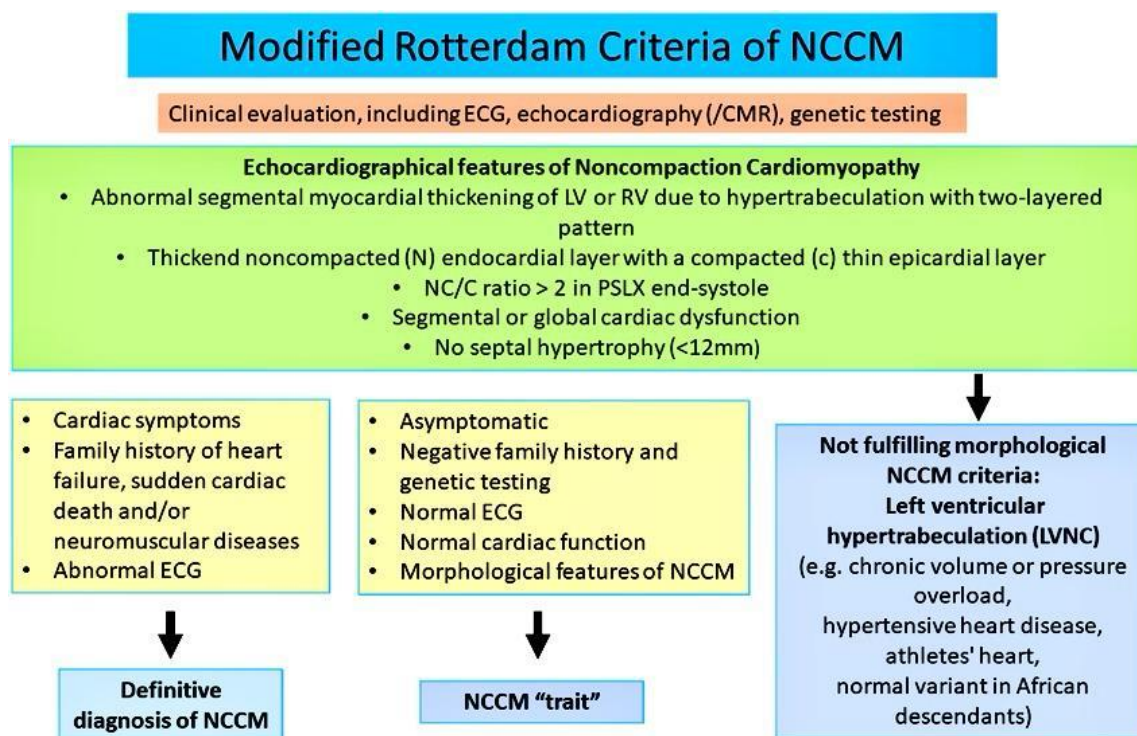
Diagnosing NCCM according to the Rotterdam criteria.^[12] LVNC left ventricular noncompaction, NCCM noncompaction cardiomyopathy, NMD neuromuscular disease, PSLX parasternal long axis view.
